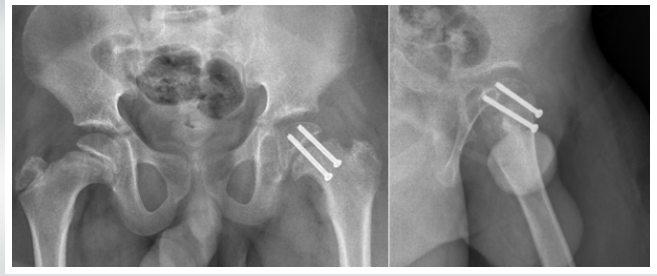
(a and b) Anteroposterior and lateral plain radiograph showing in-situ fixation with two 6.5 mm partially threaded Cancellous Cannulated screws, screws remained perpendicular to the physis.
